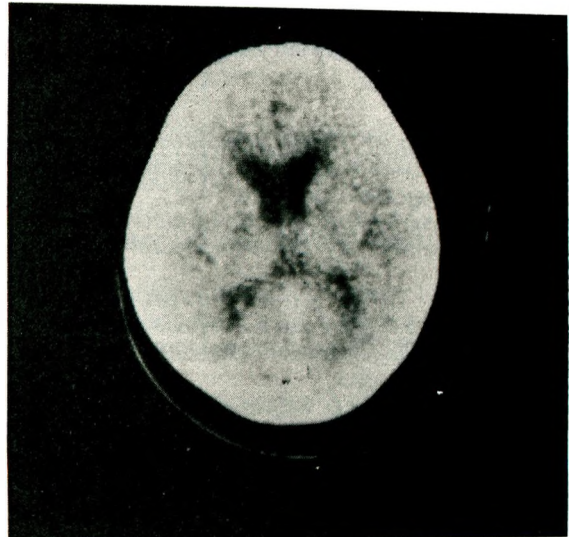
CT scan on the fiftieth day of the illness demonstrated the disappearance of the contrast enhancement and non-enhancing lesions of decreased density was present in subcortical white matter.
